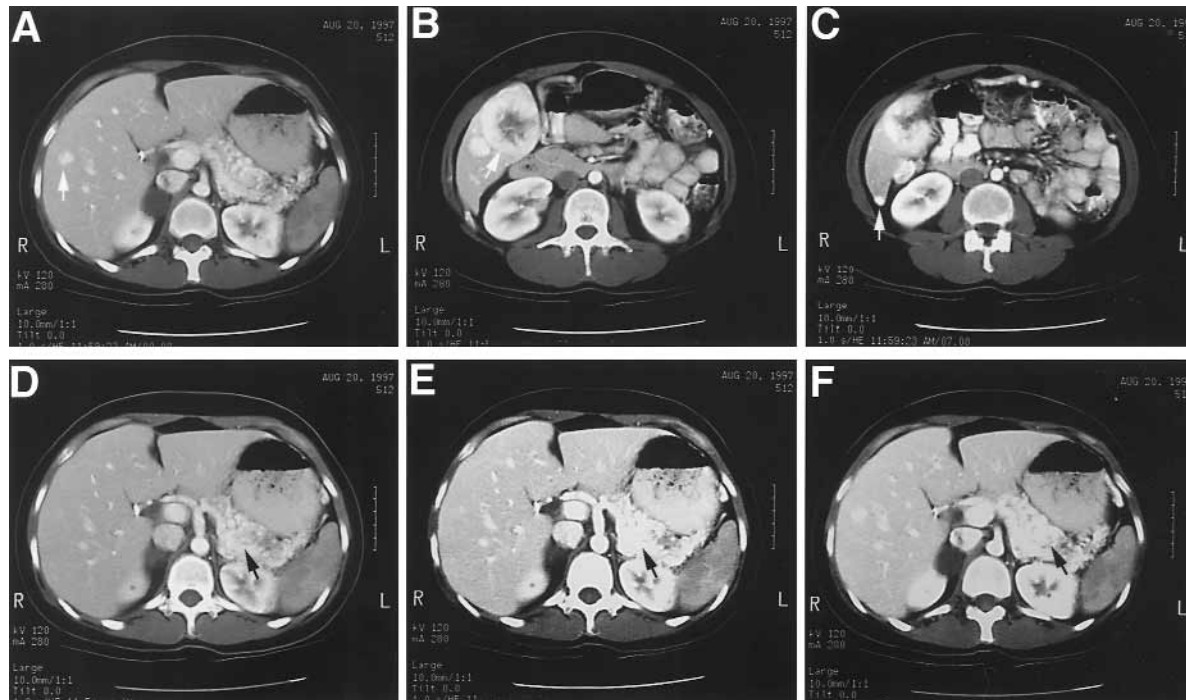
CT scans of a patient with a large solid lesion in the tail of the pancreas with synchronous liver metastases. A-C demonstrate multiple (*arrows*) hepatic metastases. D-F show a large infiltrating mass in the tail of the pancreas, which enhances on contrast CT.
